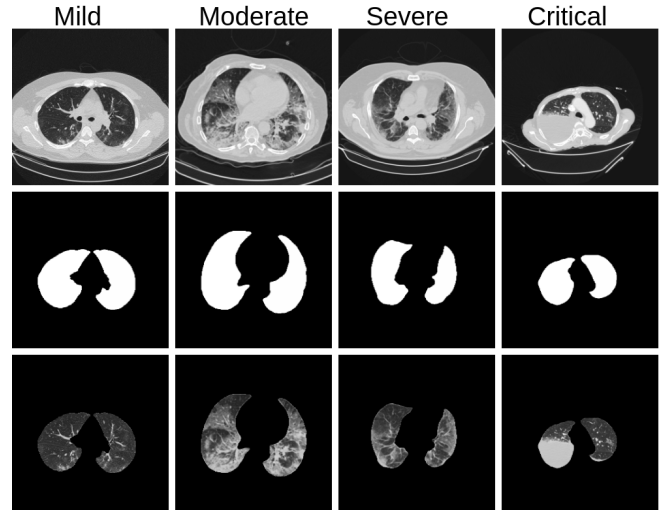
First row represents CT scan images of mild, moderate, severe, and critical categories provided in the challenge. The second row shows the lung mask generated from the images. The third row depicts the segmented region of interest for further analysis of each category.
